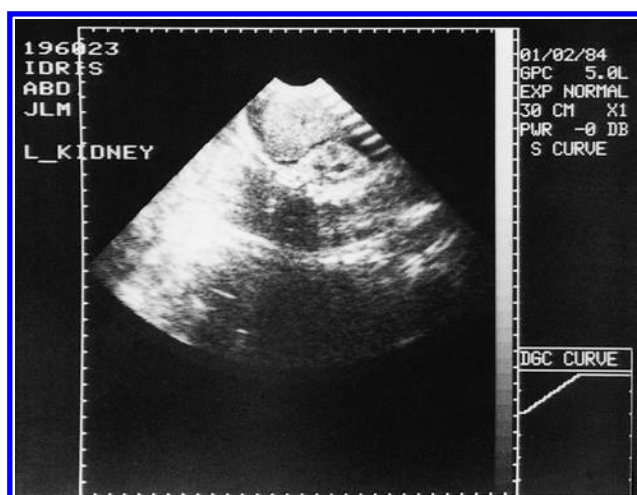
Ultrasound of the left kidney shows a dark acoustic shadow resulting from the calcification in the adrenal.
